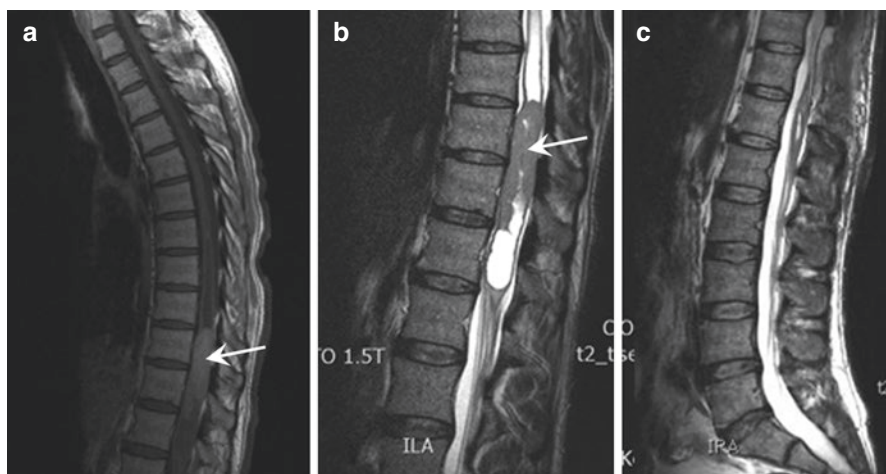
Imaging of a 45-year-old female patient who presented with paraparesis and urinary retention (patient operated on by IO). Preoperative MRI of the spine: (a) sagittal post-contrast T1-weighted MRI showing cystic contrast-enhancing tumor (arrow) at T10–L1; (b) intratumoral cyst with syringomyelia is best seen in sagittal T2-weighted MRI (Type IV B). (c) Postoperative sagittal T2-weighted MRI of the spine showing the complete resection of the tumor with resolution of syringomyelia
